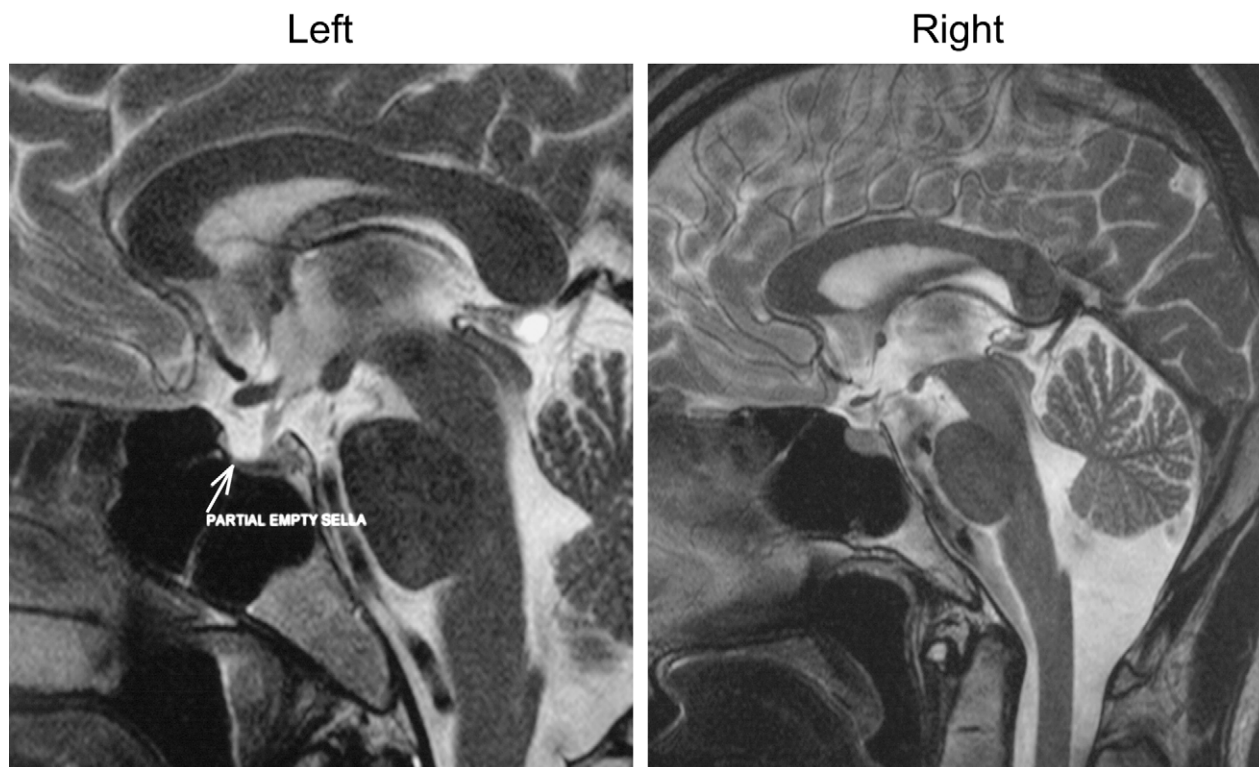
Right*: Normal MRI finding. *Left*: MRI showing a partially empty sella (arrow). (Courtesy of Carlos Buitrago Téllez, MD, University Hospital Basel, Switzerland.)
